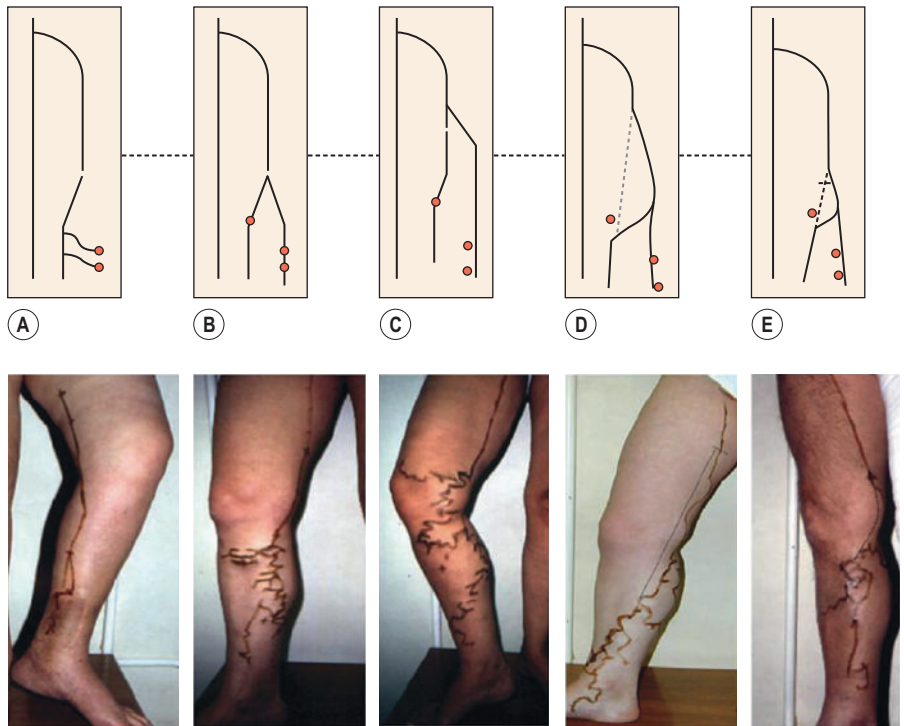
A, A single great saphenous vein (GSV) running through the saphenous compartment, with no large parallel tributaries. B, The GSV divided into two parallel vessels, both running through the saphenous compartment. C, The GSV running through the saphenous compartment, plus a large subcutaneous collateral piercing the fascia. D, Two veins, the GSV and the anterior accessory saphenous vein, in two separate 'eyes' in the proximal part of the saphenous compartment. E, No GSV visible in the distal part of the saphenous compartment, but in the outside compartment in a subcutaneous collateral acting as a GSV substitute pierces the superficial fascia, becoming the 'true' GSV. (From Ricci S, Georgiev M. Ultrasound anatomy of the superficial veins of the lower limb. *J Vasc Technol* 2002;26:183.)
